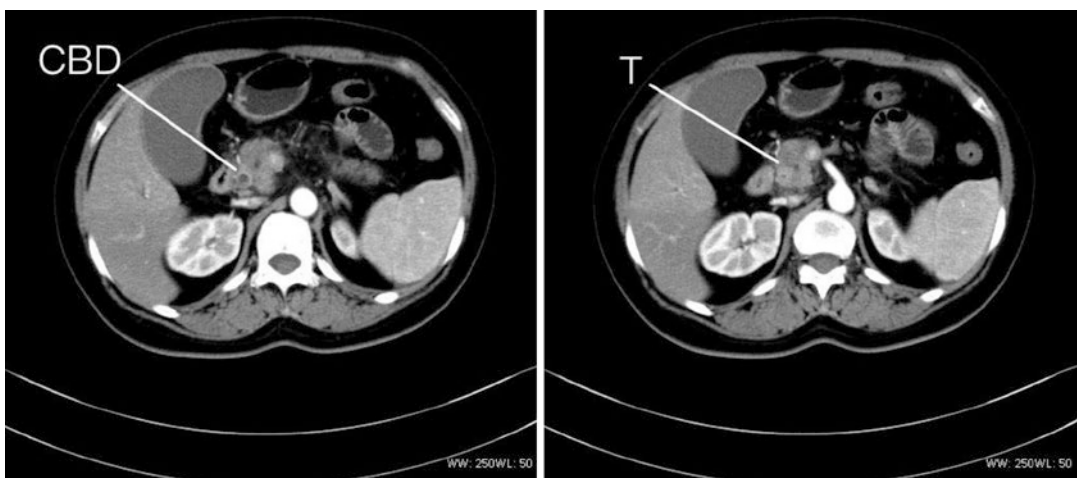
CT scan showed an arterial enhanced 2.0 \times 1.8 cm mass, detected in the head of pancreas, and thickening and enhancement of the common bile duct wall. CBD, common bile duct; T, tumor
